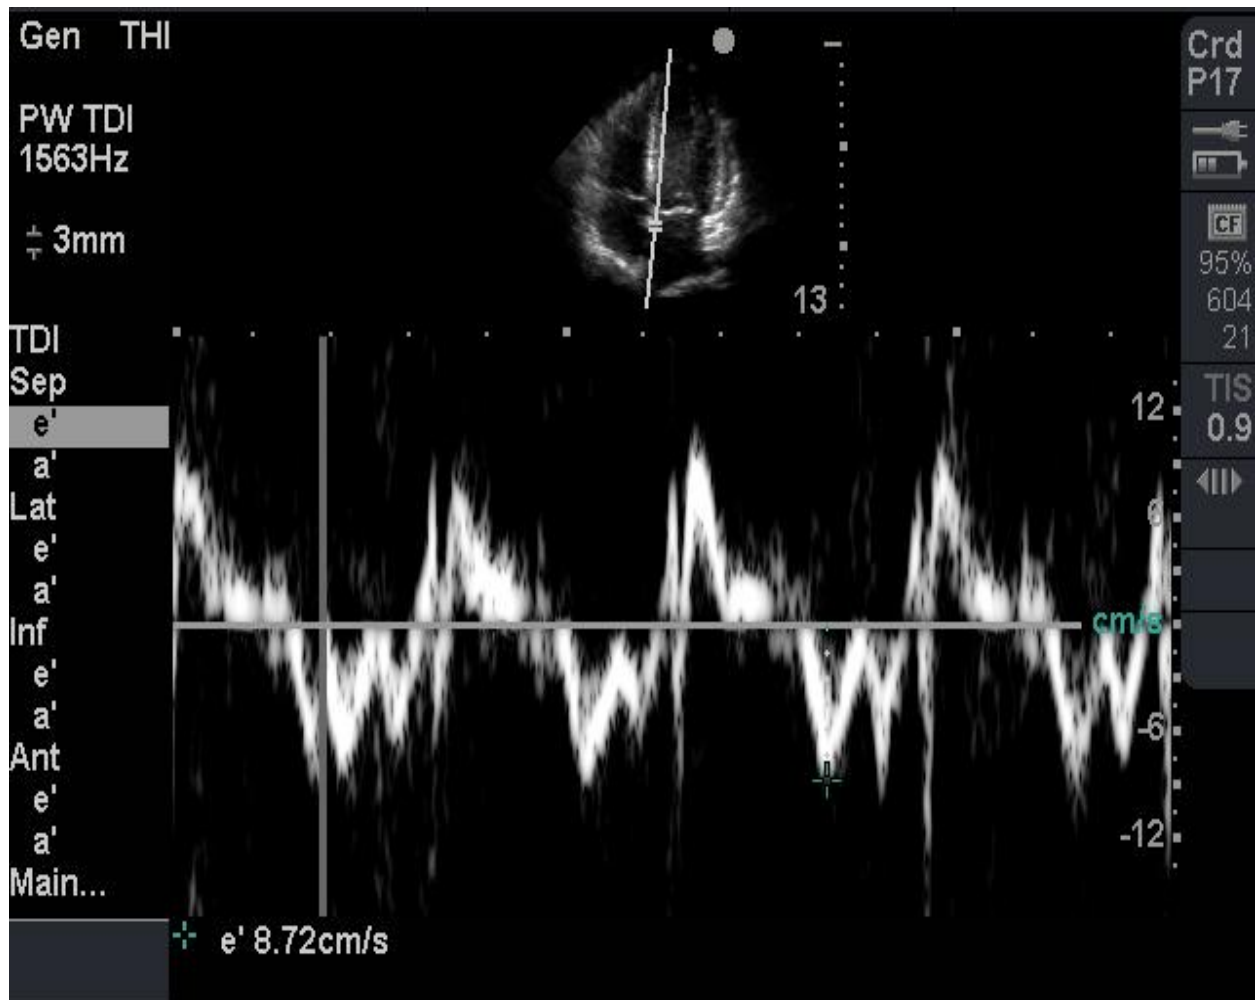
Measurement of e' on the medial annulus tissue Doppler trace
